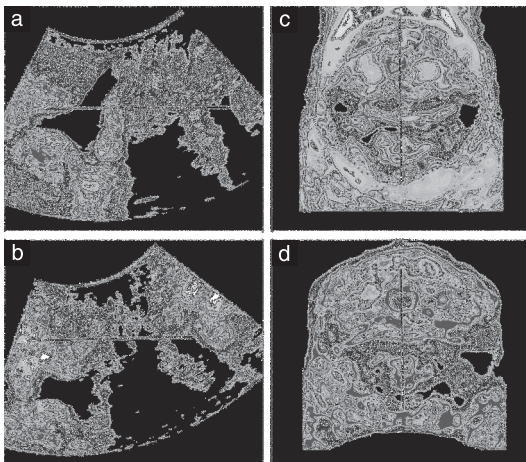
Sonographic images of levator ani muscle macrotrauma. (a,b) Two-dimensional images in midsagittal view in plane of minimal hiatal dimensions, showing anteroposterior levator hiatus diameter from distal border of pubic symphysis to puborectalis muscle (lines) at rest (a) and on contraction (b). (c,d) Three-dimensional images showing anteroposterior diameter and hiatal area (solid lines and dotted lines, respectively) at rest (c) and on contraction (d).
